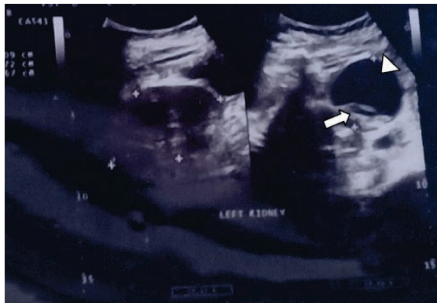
Abdominal ultrasound of left kidney. A cyst (arrowhead), intramural nodule (arrow).
